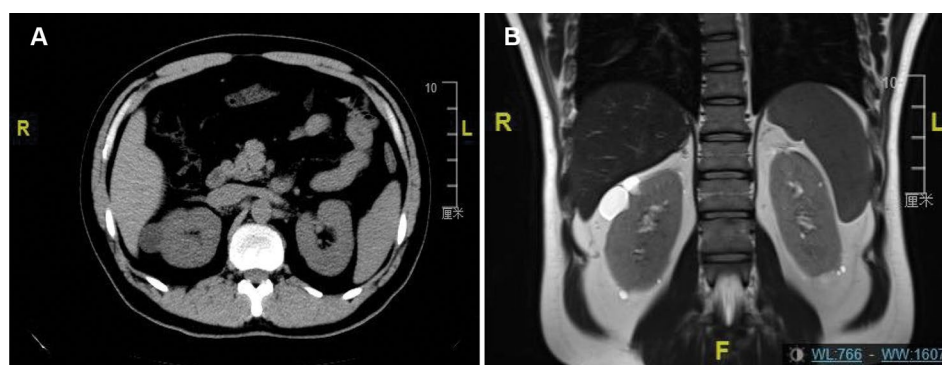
Kidney imaging. (A) Computed tomography scan showed one cyst on right kidney. (B) Magnetic resonance imaging showed numerous small cysts on both kidneys besides the large cysts
